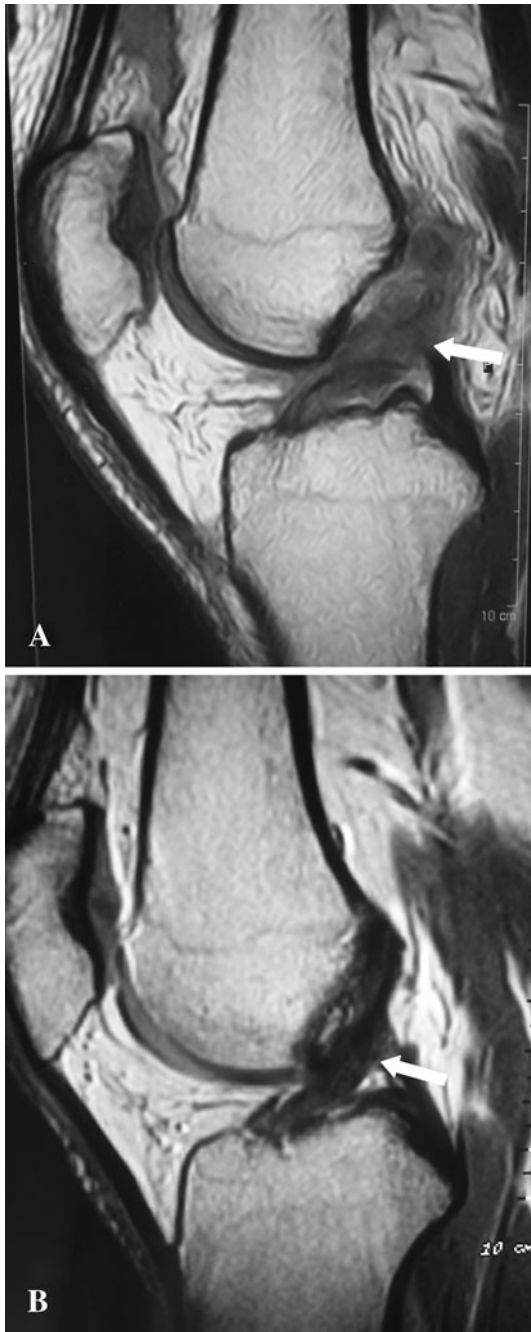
B (A) A MR image shows a midligament rupture with increased signal intensity and edematous mass-like shape (arrow). (B) A MR image sagittal view performed 2 years after the injury shows a continuous ACL (arrow).
